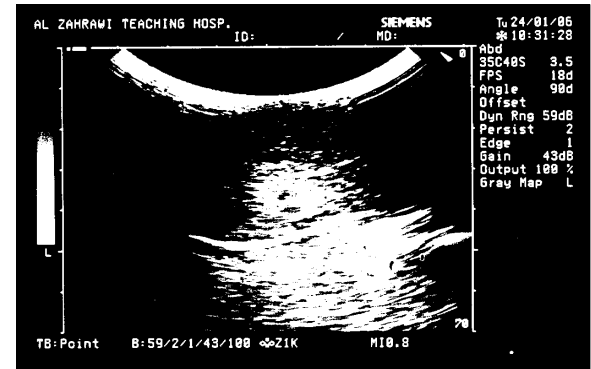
Abdominal ultrasound of group D showing normal hepatic echoes, no abnormal masses.
